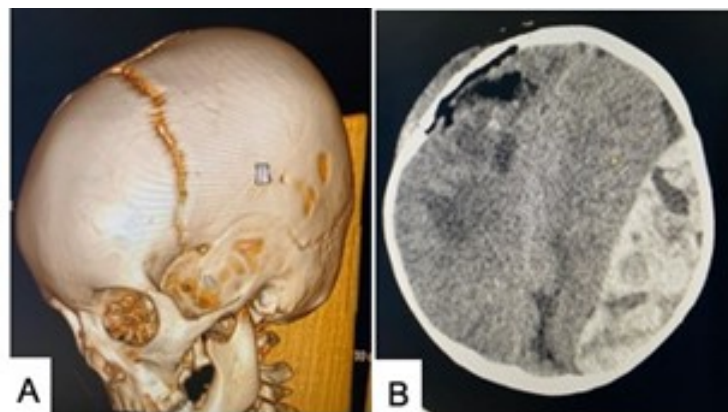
(A) A 3D CT scan showing a depressed fragment in temporal bone. (B) A huge EDH found in the temporo-parietal region of the same patient. Source: Figure by authors.
